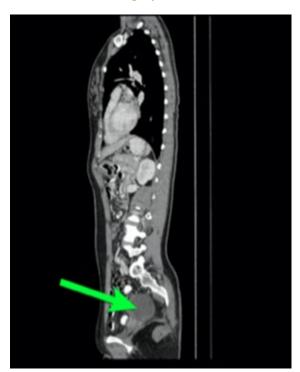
Sagittal view of CT-TAP prior to the second surgery.
